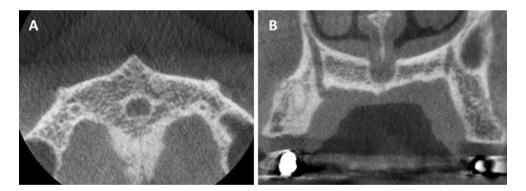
Axial (a) and coronal (b) CBCT slices showing the presence of the accessory canals, completely distinct from the nasopalatine canal
